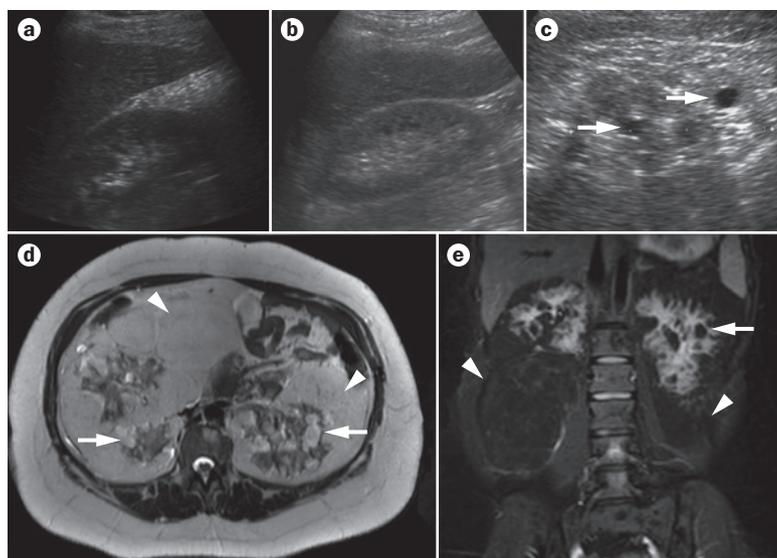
Renal manifestations of rare cystic kidney diseases. a | Ultrasound scans showing nephronophthisis in an adult patient with Senior-Løken syndrome and multiple small renal cysts. b | Ultrasound scan showing nephronophthisis in an adult patient with medullary cystic kidney disease. c | Ultrasound image from a patient with Bardet-Biedl syndrome, showing small kidneys with multiple renal cysts (white arrows) and increased echogenicity. d | Axial T2-weighted MRI scan and e | coronal fat-suppressed MRI scan of a patient with tuberous sclerosis complex, showing cystic kidney disease (white arrows) and huge bilateral renal angiomyolipoma (white arrowheads).
